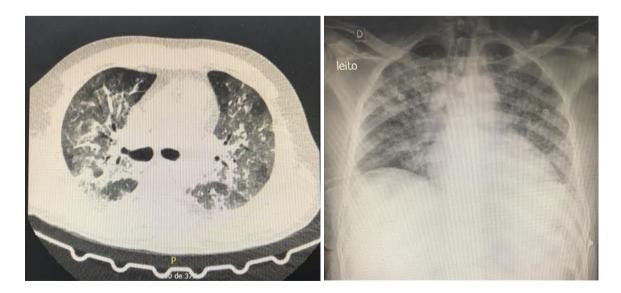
Computed tomography scan and radiograph of the thorax indicating damage by SARS-CoV-2 infection. Brazil, 2021.
